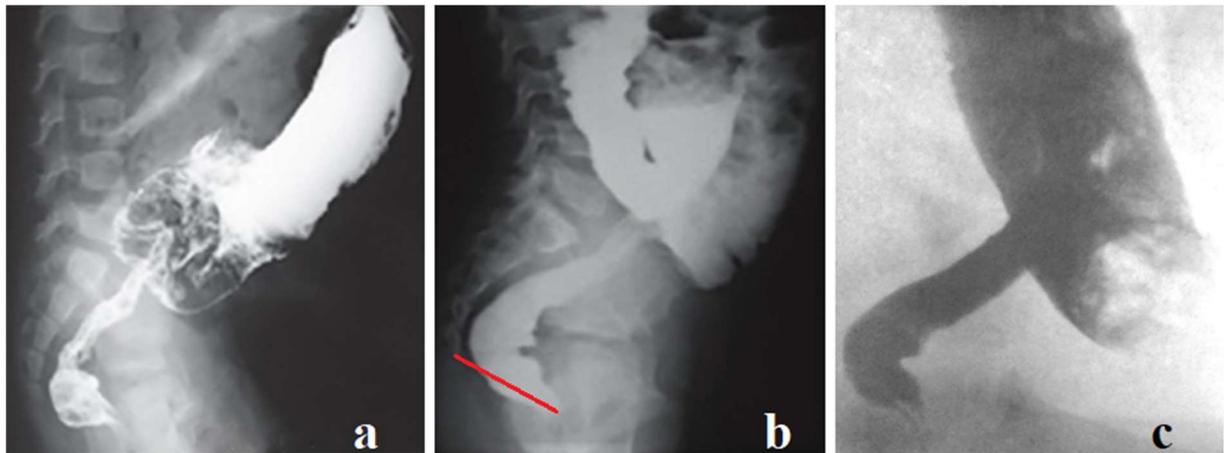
Lateral radiographs of patients with HD. In each case, a small horizontal branch of the rectum and a significant narrowing of the rectum are determined. (a-b) From article Oulad Said [15].
